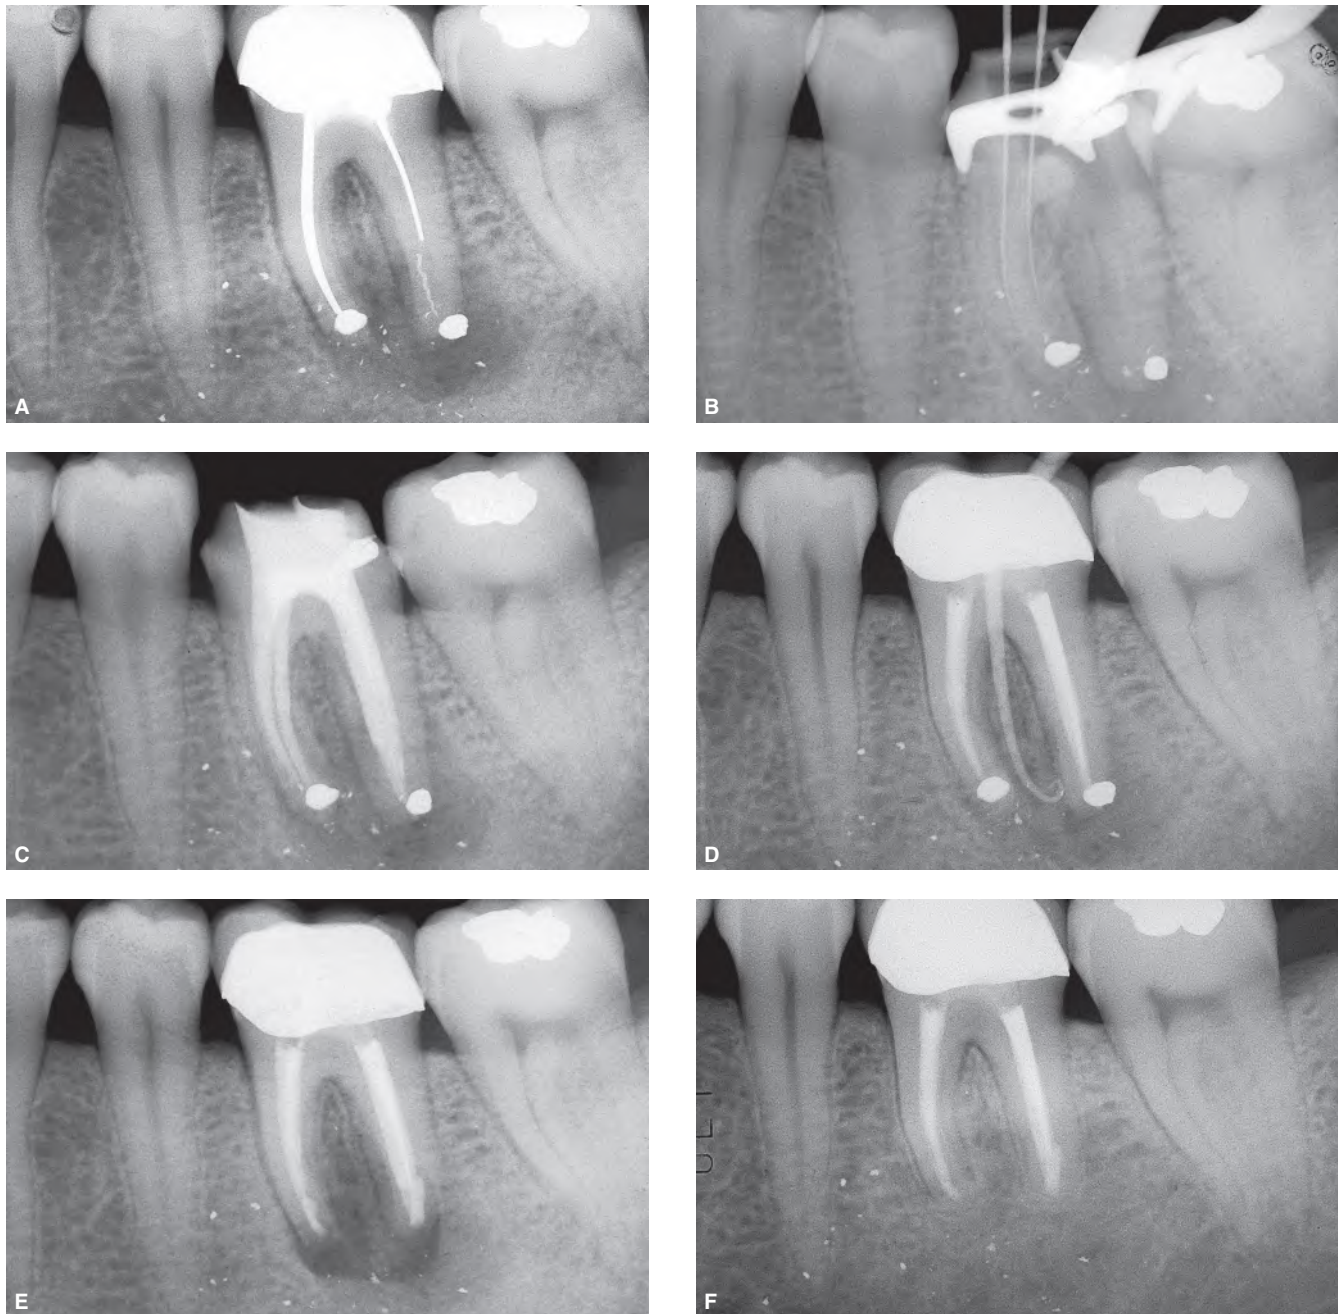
A. Preoperative radiograph of a mandibular left first molar. The tooth was obturated with silver cones. A separated instrument is also present in the distal root. B. Intraoperative radiograph during non-surgical retreatment. The silver cones and the separated instrument were successfully removed. C. Immediate postoperative radiograph. D. Six-month follow-up radiograph. A sinus tract is now present. At this point, surgical retreatment was carried out. E. Postoperative radiograph following surgery. F. Two-year recall radiograph showing a healing of the bony lesion.
